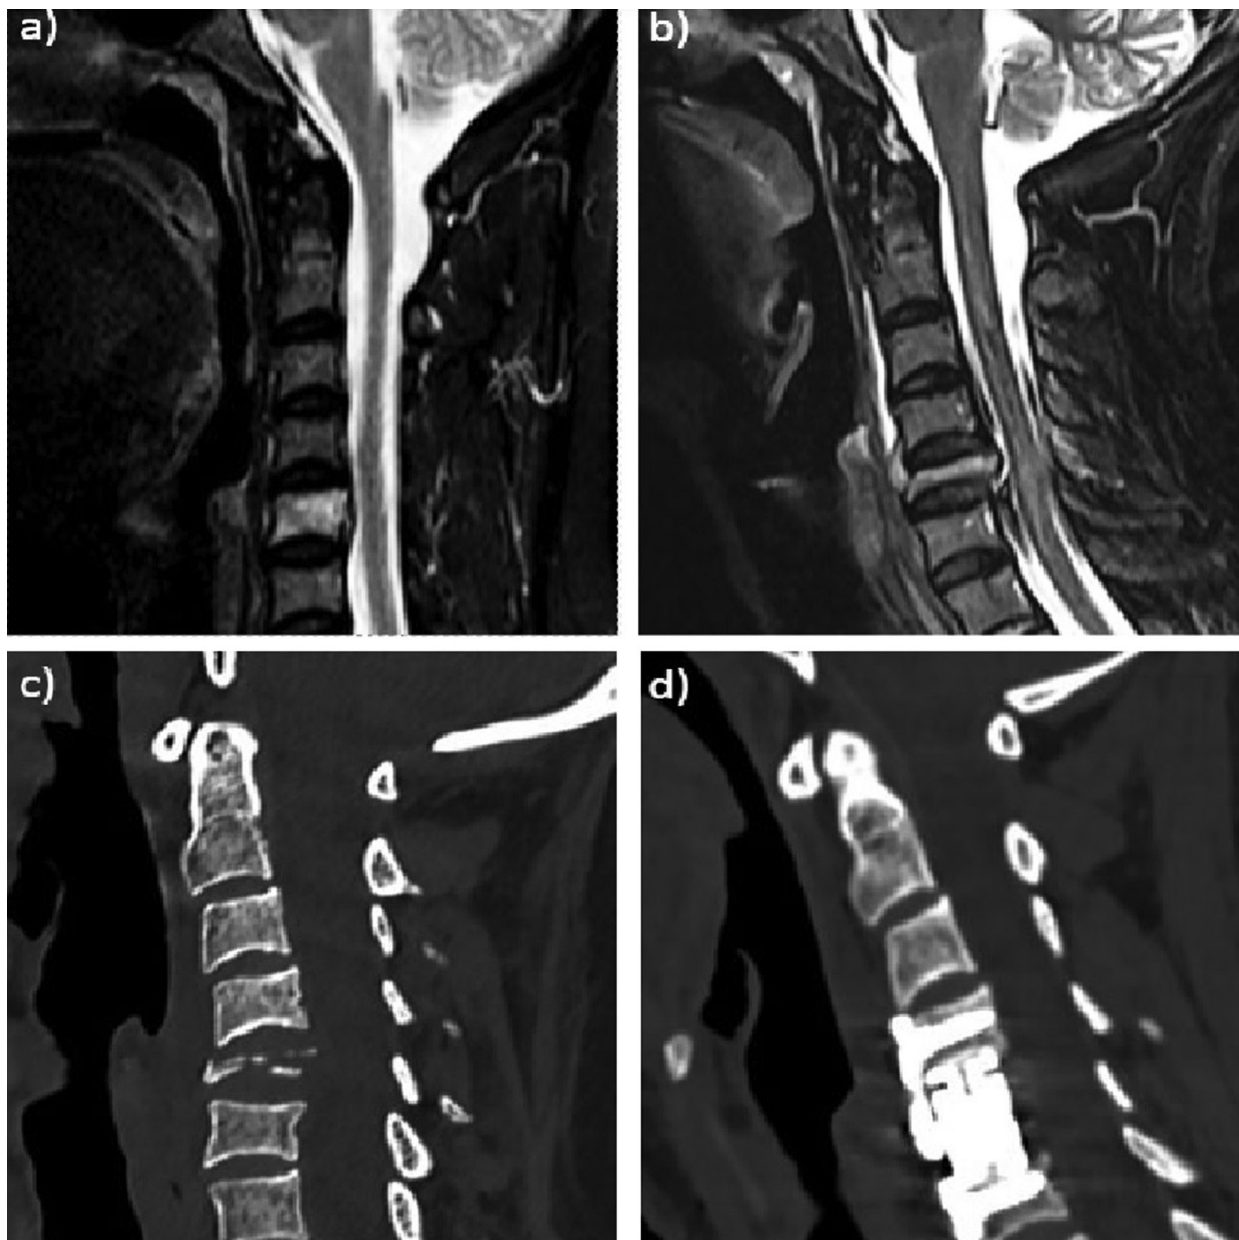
Radiological imaging of a 37-year-old female patient with C5 and T7 vertebral bone involvement a) MRI was taken when the patient presented with neck pain. There is height loss in the C5 vertebral body and edematous appearance in PLL. b,c) MRI and CT took after the patient complained of pain and weakness in the left arm two weeks later. There is a height loss of more than 75% in the C5 vertebra and mild narrowing of the spinal canal. d) CT of the patient after C5 vertebra central and left partial corpectomy and anterior plate application with C4 and C6 corpal screws.
